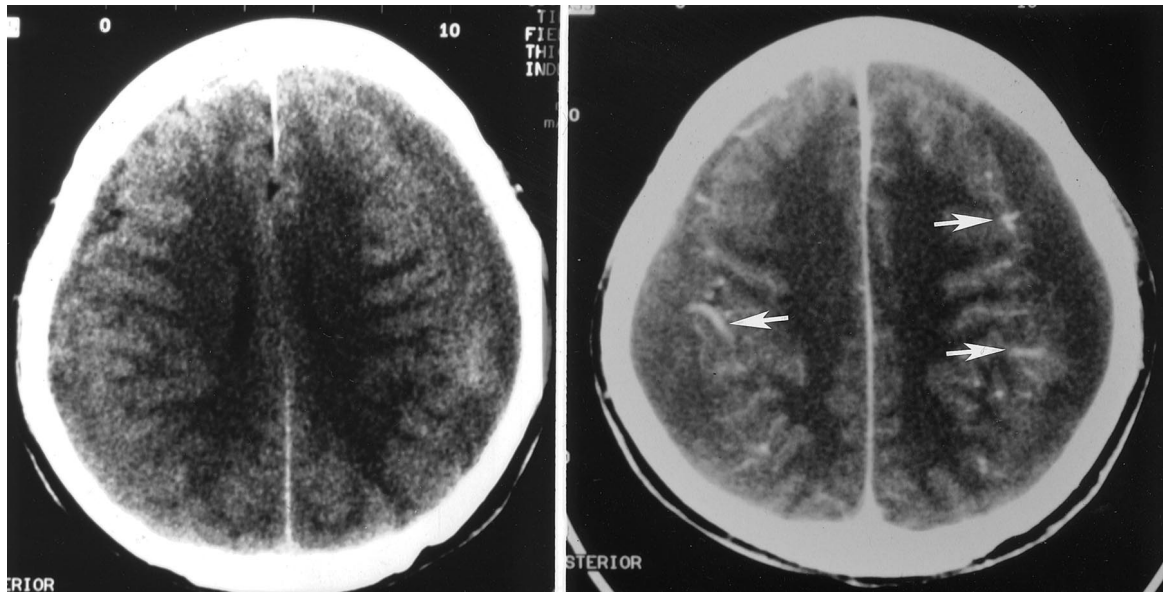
Noncontrast brain CT scan (left) shows isodensity in extra-axial region. Contrast CT scan (right) shows the isodense lesions with enhancement and medial displacement of cortical veins (arrows), indicating bilateral chronic subdural hematomas.
